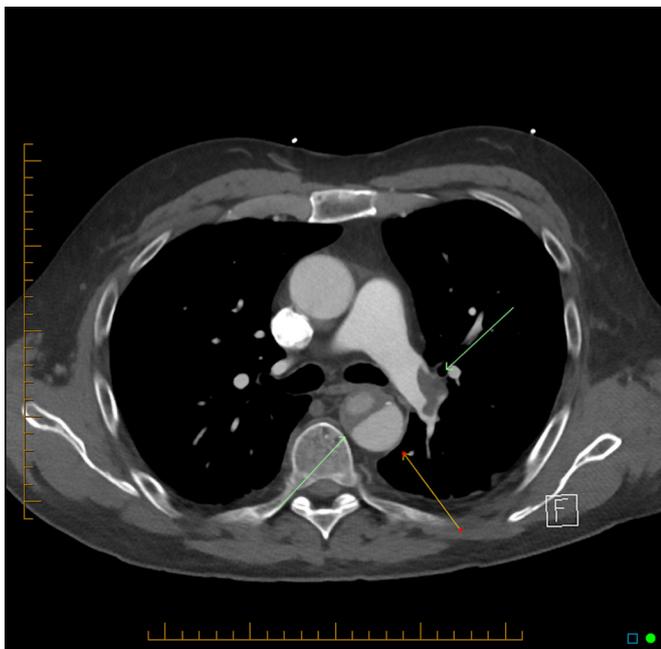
Transverse view CT image demonstrating a type B aortic dissection and large filling defect in the pulmonary trunk.
